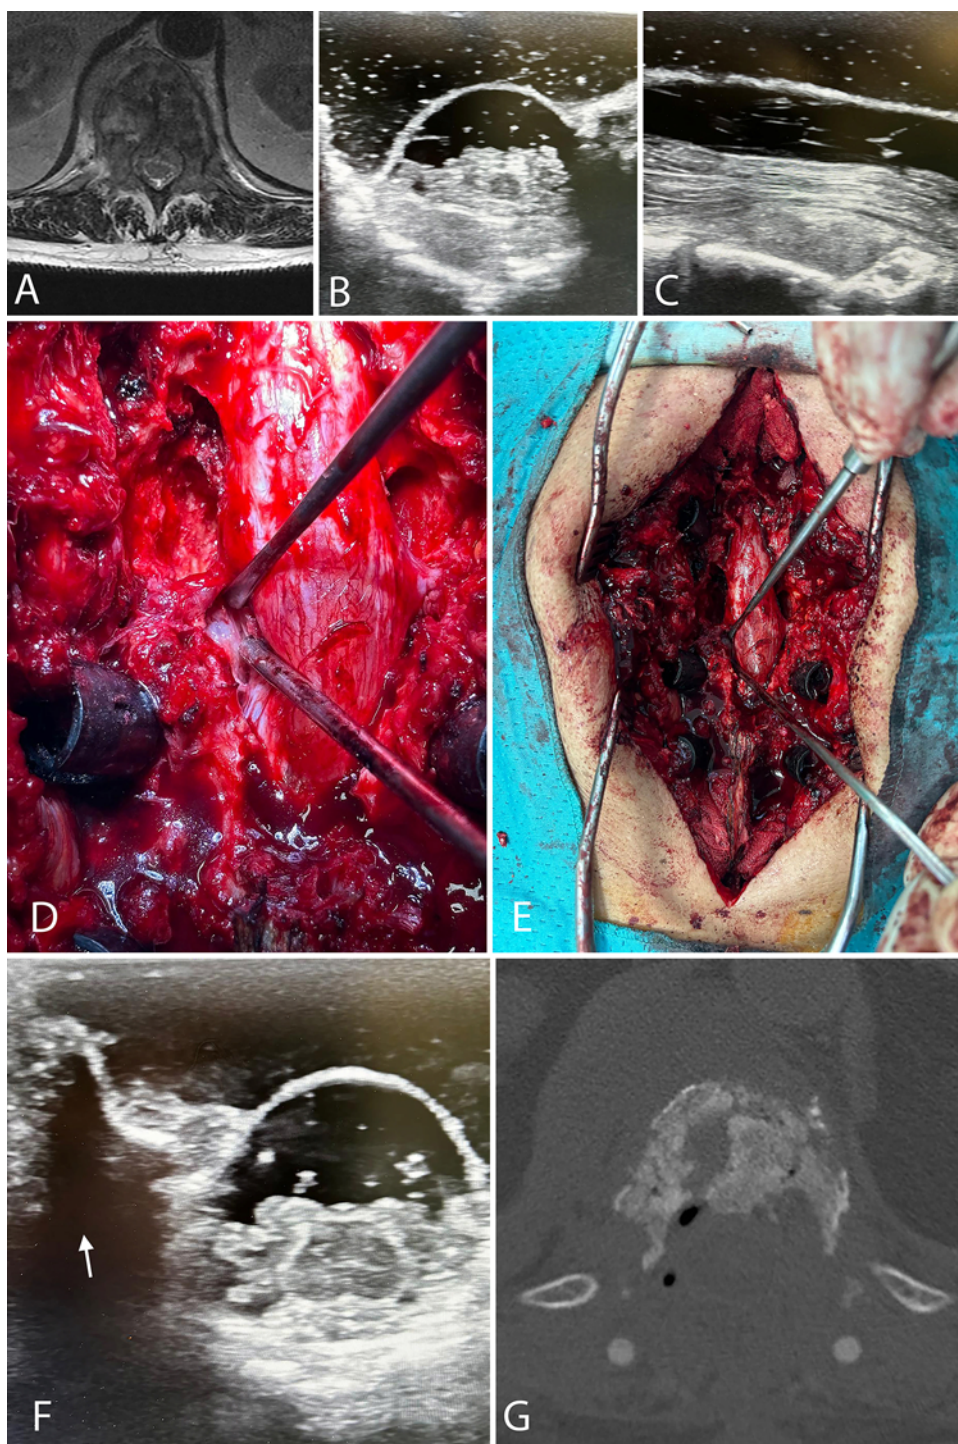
Images and intraoperative photographs obtained in the case of a 56-year-old man with renal cell carcinoma complaining of mechanical axial pain and thigh numbness. A: MR image showing a T12 mixed lesion with vertebral body partial collapse and Bilsky grade 2 ESCC. Instability (SINS of 9, NSE score of 7) and the need for surgery were assessed. B and C: Intraoperative coronal (B) and sagittal (C) ultrasound images showing tumor compression on the ventral aspect of the cord. D and E: Intraoperative photographs showing the effective 360° decompression, achievable from a posterior approach through the transpedicular bilateral approach. F: Intraoperative ultrasound image showing tumoral decompression, safe CSF margins for further radiotherapy, and the transpedicular route (arrow). G: Postoperative CT scan revealing the entity of decompression on the ventral site.
